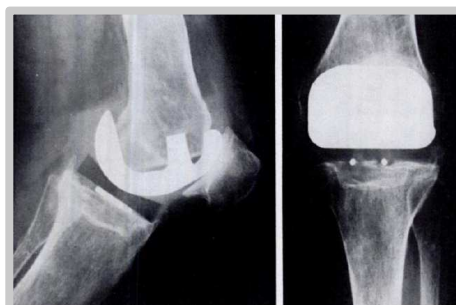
Freeman-Swanson knee and a postoperative ICLH radiograph (from Gibbs A. N. et al. 1979 JBJS)
